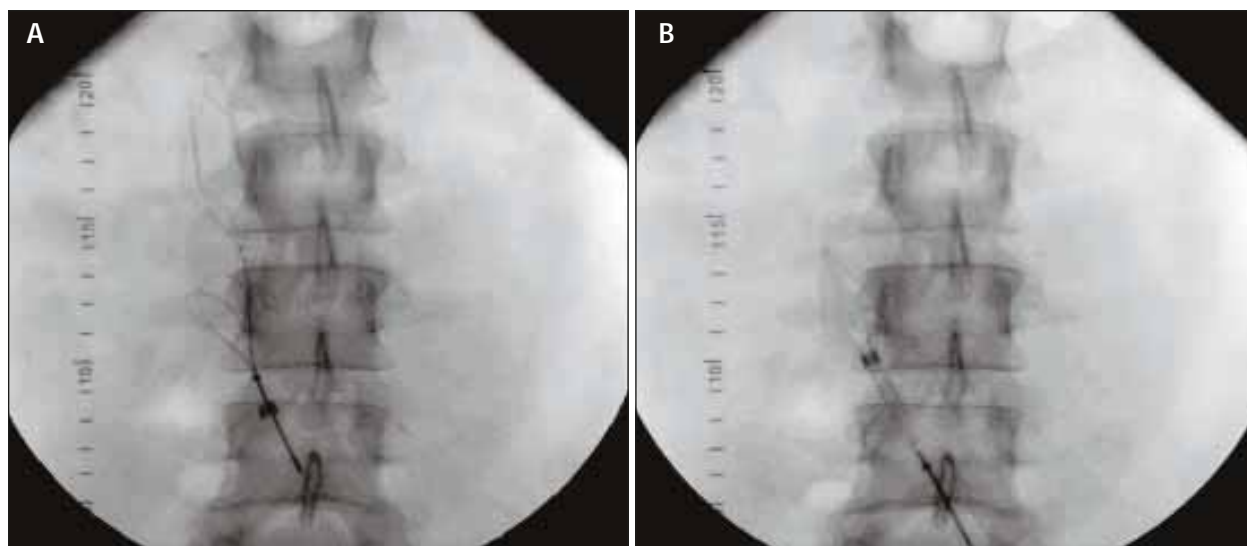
OptEase filter retrieval (A). Note filter hook engaged by snare. Ensnared OptEase filter recaptured into a 12-F sheath by advancing the sheath over the snare and filter (B). (Reprinted with permission from Rosenthal D, Wellons ED, Levitt AB, et al. Role of prophylactic temporary IVC filters placed at the ICU bedside under intravascular ultrasound guidance in patients with multiple trauma. *J Vasc Surg.* 2004;40:958-964).
